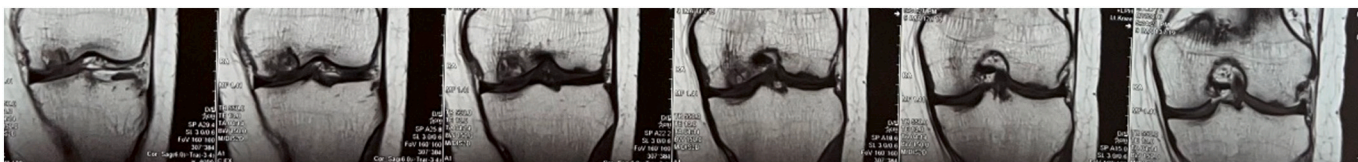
MRI of the left knee preoperative.
